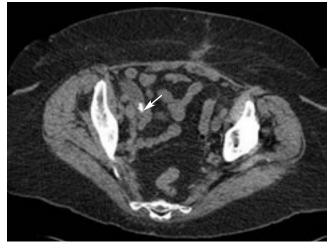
Nonenhanced computed tomographic scans. Left, right hydronephrosis (arrow), with some stranding of the perinephric fat. Right, an irregularly shaped calculus (arrow) is lodged within the midportion of the dilated right ureter, causing the hydronephrosis.
